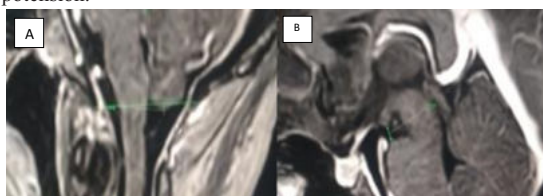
Post Contrast Sagittal Sections T1W MRI Image Of Brain -A) Mild Tonsillar Decent, B) Reduced
